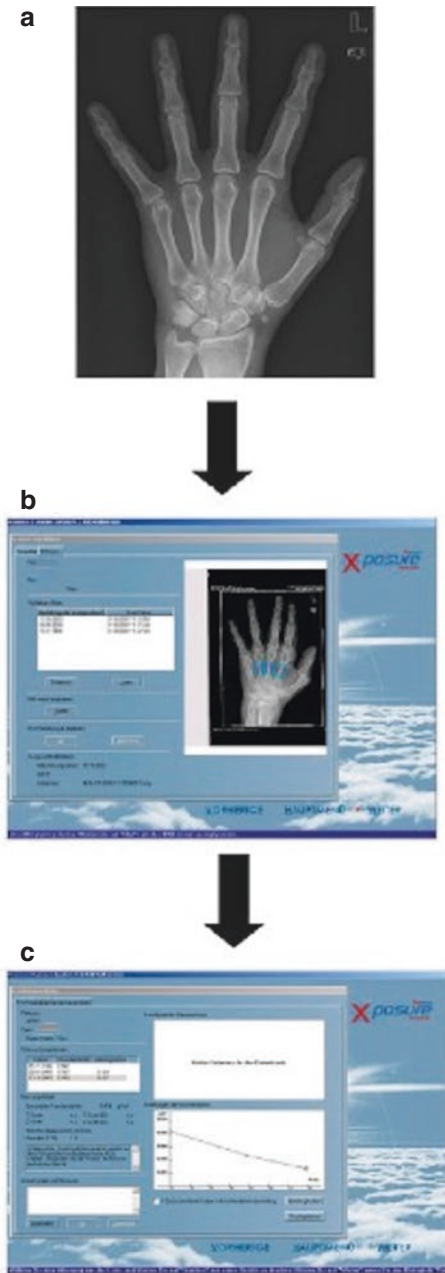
Hand bone density measurement by digital X-ray radiogrammetry (DXR). (a) Radiographs are scanned in digital X-ray radiogrammetry (DXR) system. (b) Screen view of DXR with the marked region of interest positioned at the metacarpal diaphysis II–IV (see Fig. 22.5 for a close up). (c) Screen view of the scanning protocol. The coefficient of variation (CV) of DXR measurements in the hands of premenopausal women was 0.68% and the CV in the postmenopausal women was 0.61%. (Image from Pfeil et al. [30])
